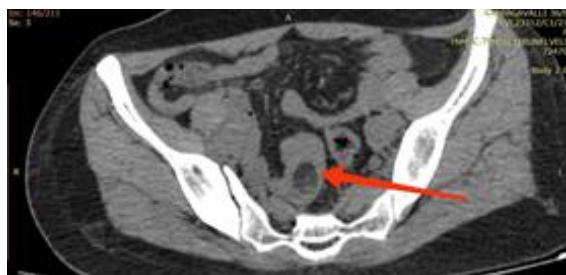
CT Abdomen showing hypodense lesion intraluminally in the ileum
